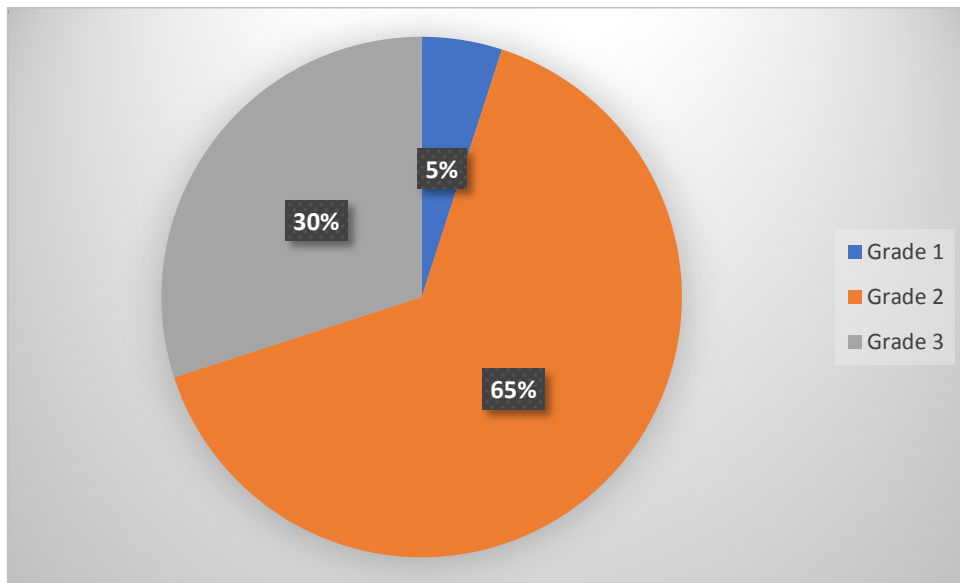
CT PNS findings among the study participants
